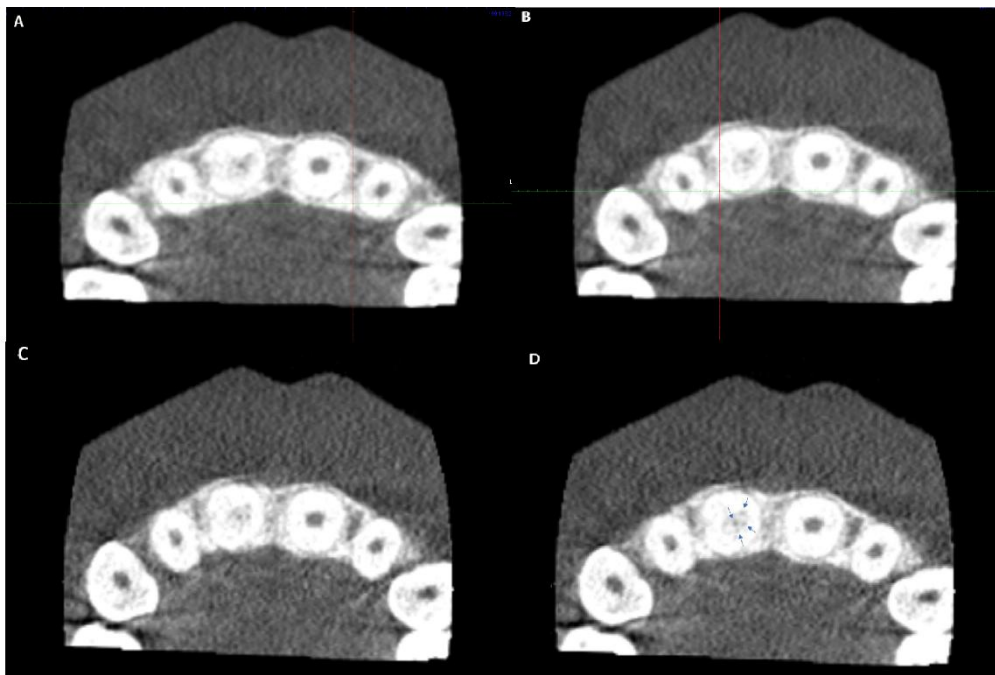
Cone-beam computed tomography image.
